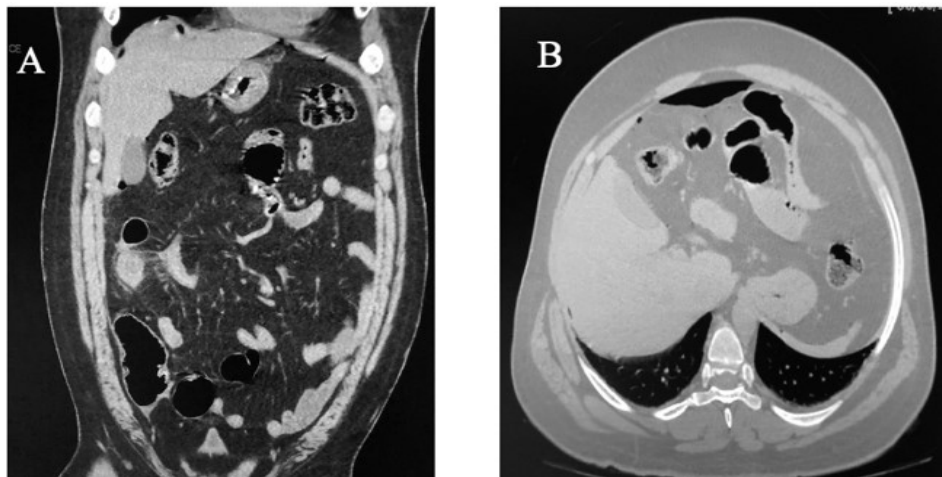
Computed tomography of the abdomen. A) Coronal CT scan with inflammatory process at the terminal ileum level B) axial CT scan with evidence of open air in the abdominal cavity.
